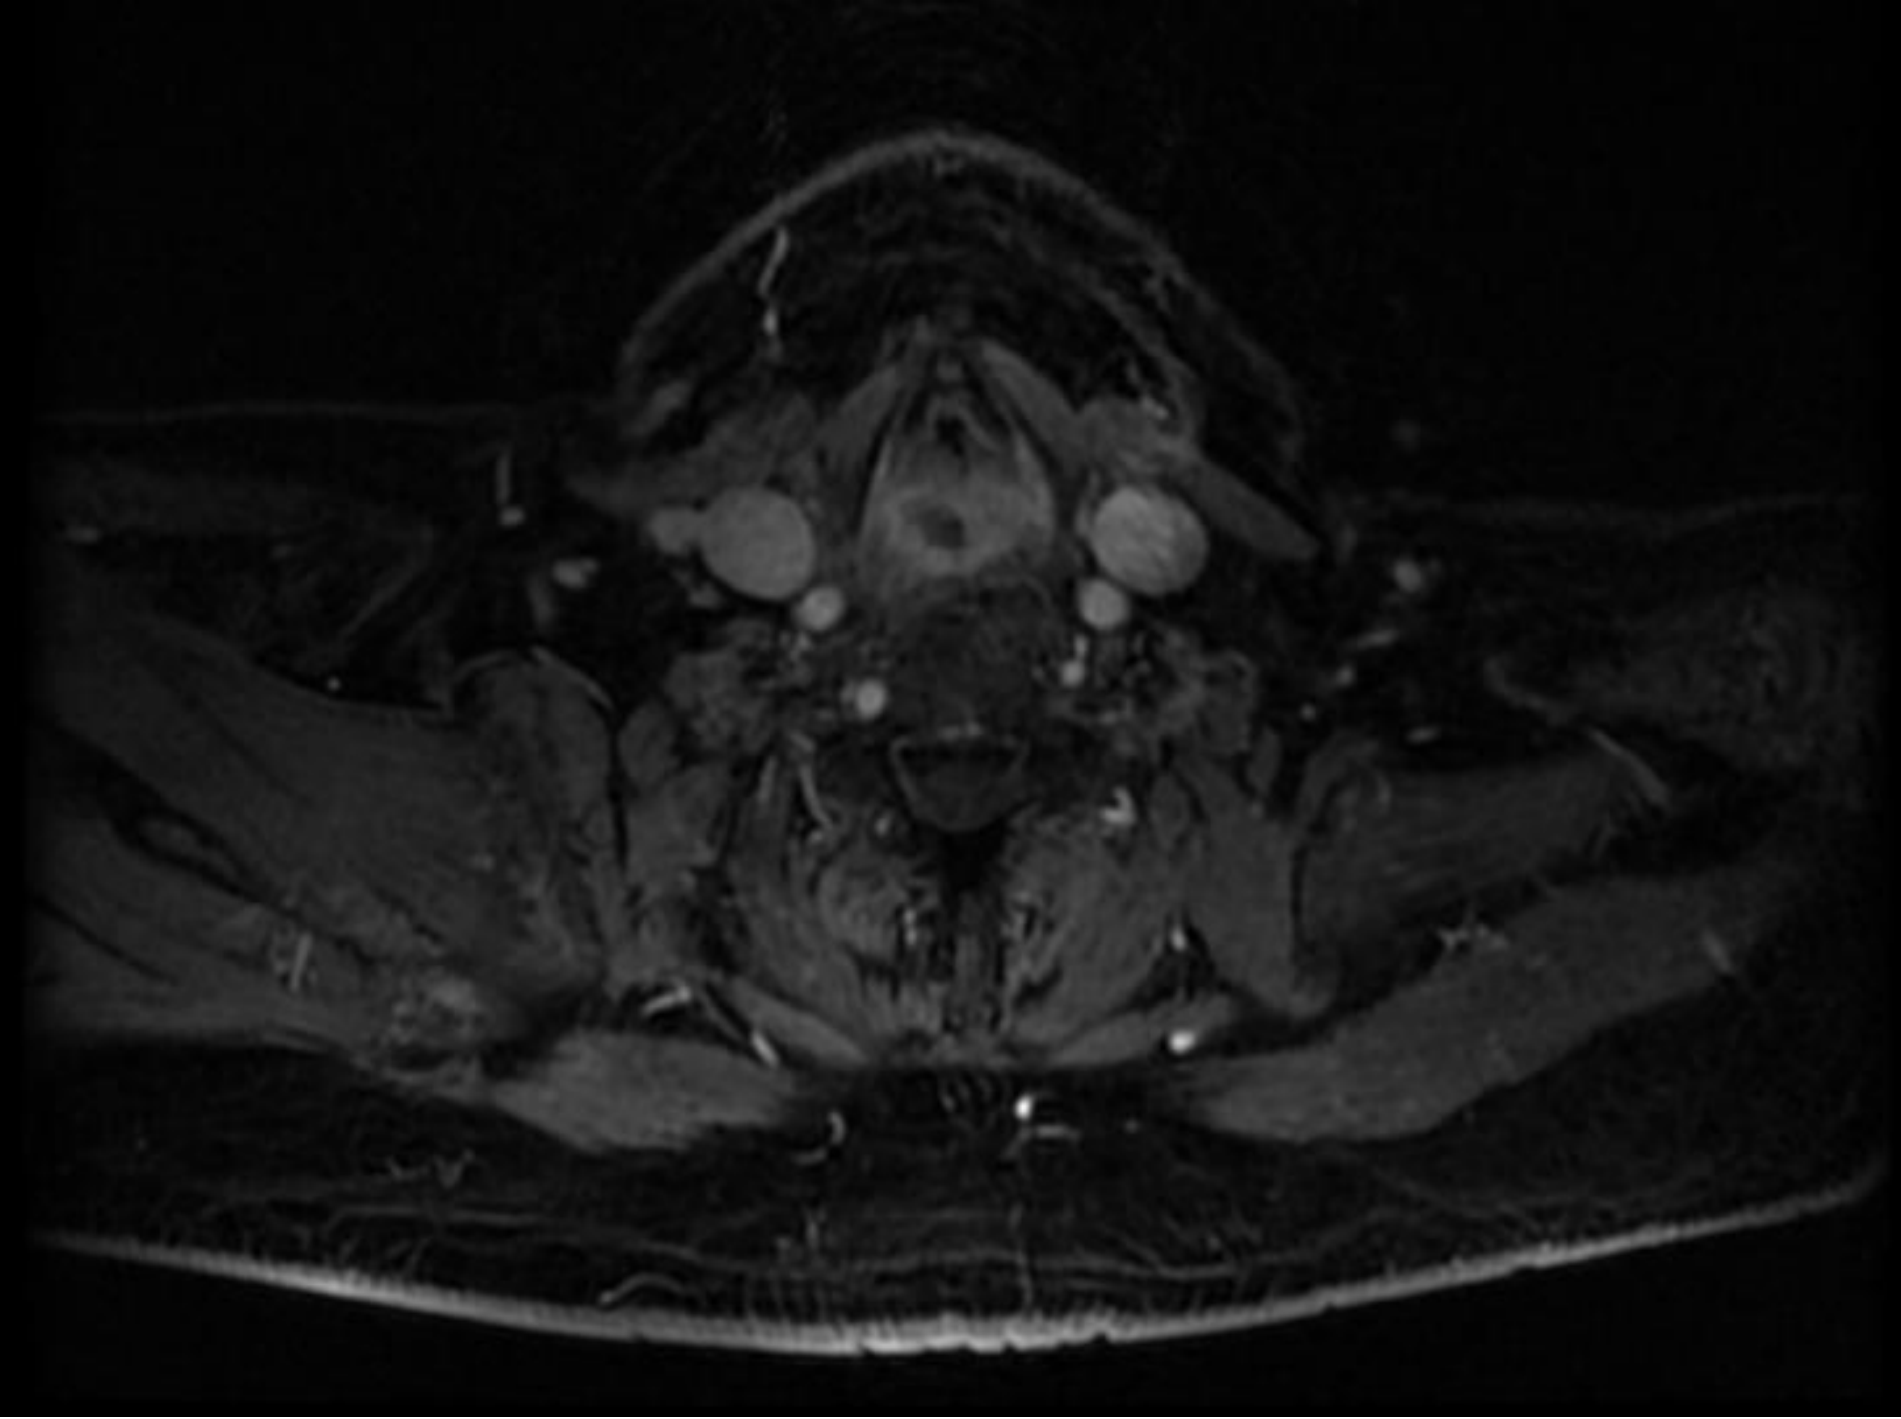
Gadolinium-enhanced-T2-weighted MR image in the transverse plane depicting high T2 signal and enhancement in the post-cricoid region, extending anteriorly to involve the false cords (particularly the right), and a cuff of enhancing soft tissue inside the cricoid.
